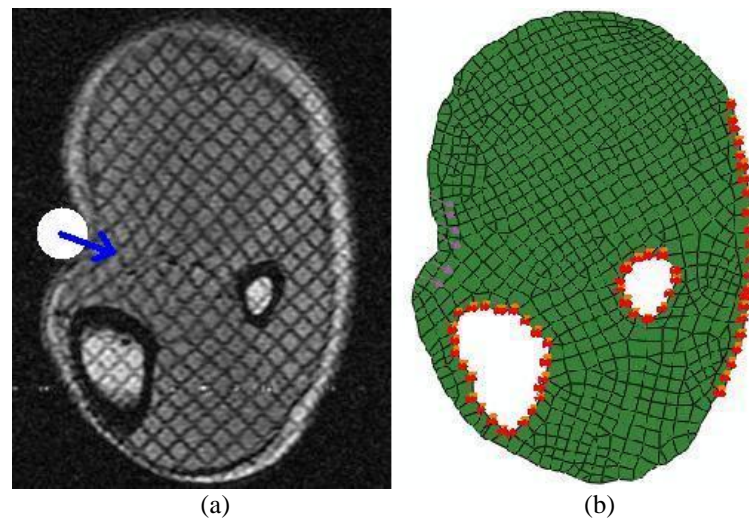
Images of human lower leg. (a) MR image, white circle represents the indenter, blue arrow represents the indentation direction, (b) FE boundary conditions
